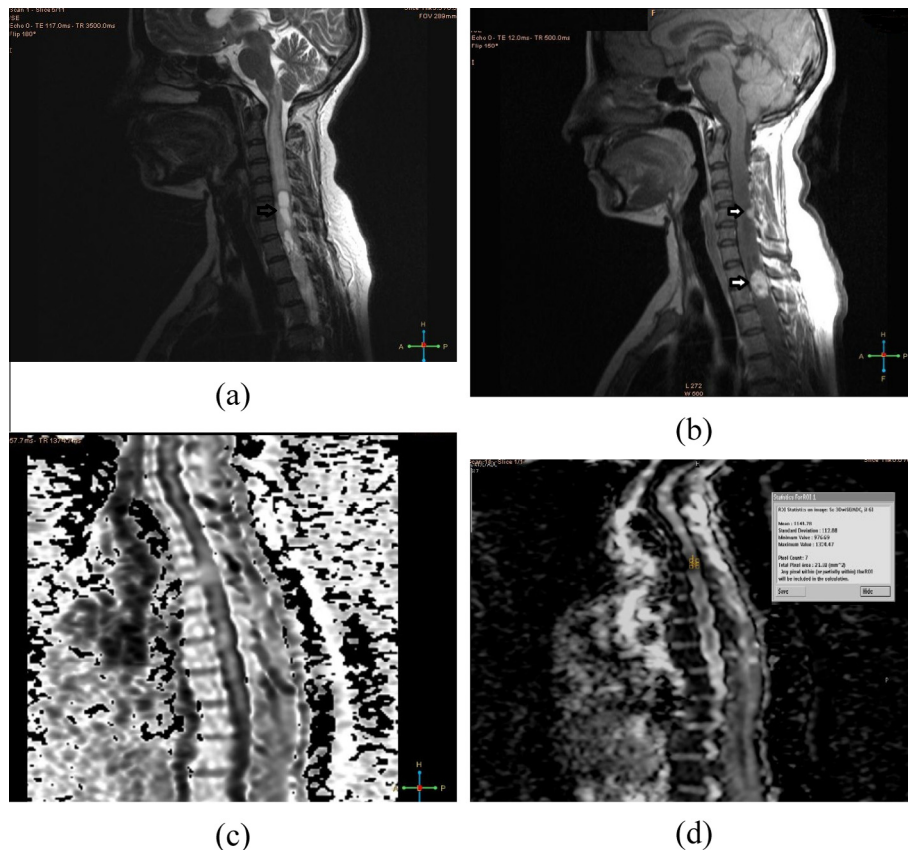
30-years-old female presented with severe neck pain and tingling. Sagittal T2-WI (A) shows a heterogeneous cystic and solid mass expanding the cord in the cervical and upper dorsal regions (arrow). Sagittal post-Gadolinium enhanced T1-weighted image (B) shows multiple enhanced portion (white arrow). DWI (C) and ADC (D) of the enhancing portion show hypointense and iso ADC ($1.1 \times 10^{-3} \text{ mm}^2/\text{sec}$) respectively. The findings of conventional MRI with DWI data, the case was diagnosed as ependymoma (low grade).
